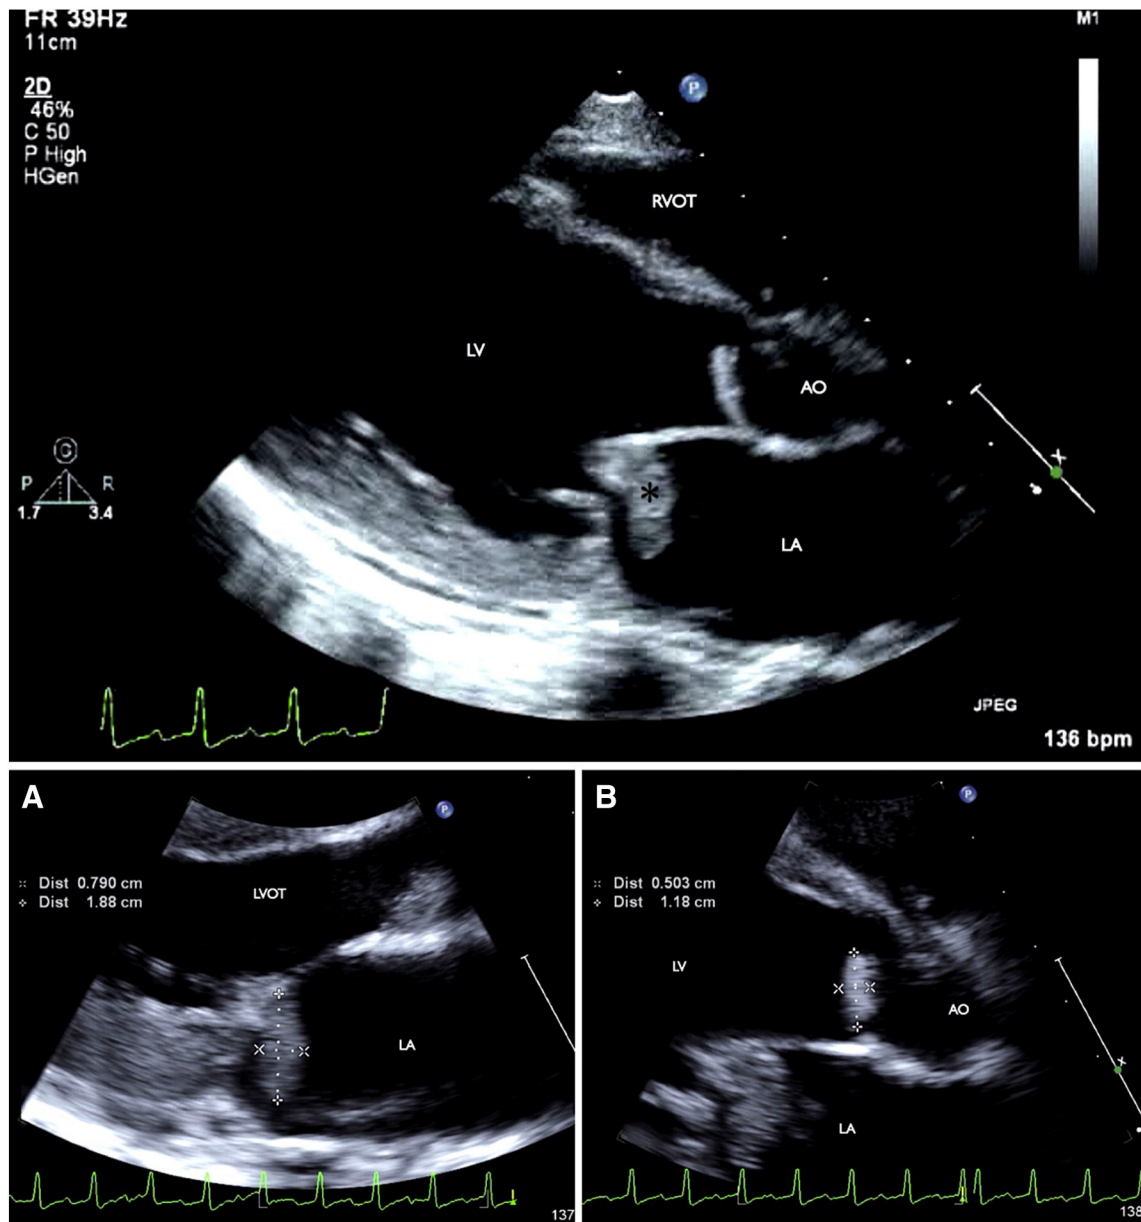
Two-dimensional echocardiogram: parasternal long-axis view (top) with magnified mitral valve in systole with vegetation of the mitral valve (A) and magnified aortic valve in diastole with pedunculated vegetation of the aortic valve (B). Abbreviations: AO, aorta; LVOT, left ventricular outflow tract; LA, left atrium; LV, left ventricle; RVOT, right ventricular outflow tract; *, vegetation.
